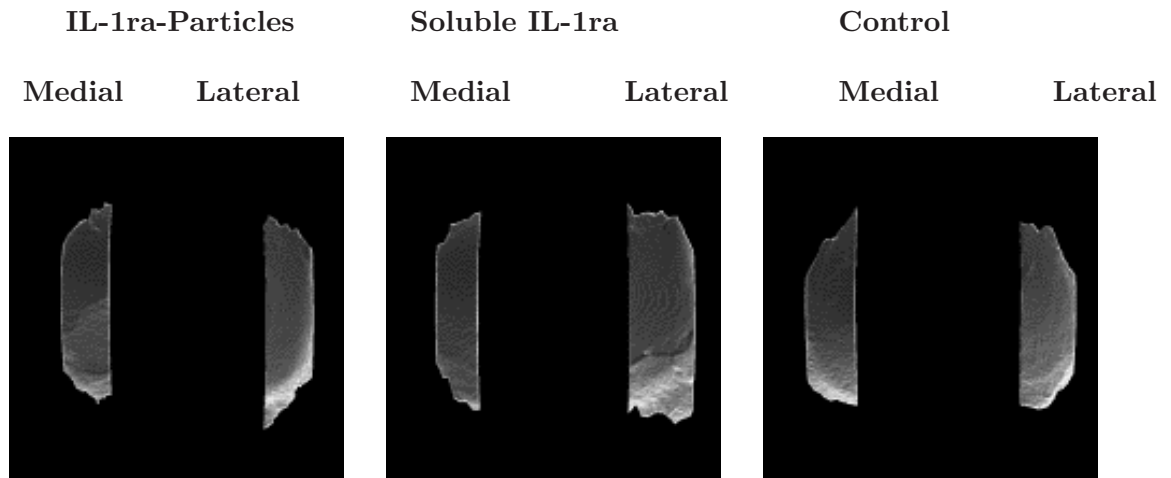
Superior View of Tibial Articular Cartilage Surface. Reconstructions of Cartilage from EPIC- μ CT Analysis. Visual comparisons confirm that there are no gross differences between cartilage receiving IL-1ra-particles versus soluble IL-1ra or PBS. Medial side, Left; Lateral side, Right.
